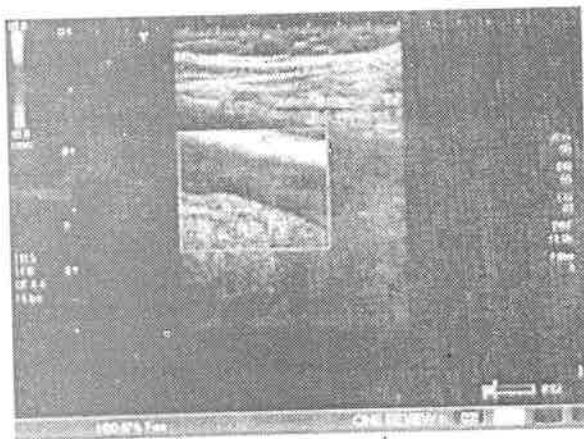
Doppler ultrasound showing a big thrombus throughout the length of the right femoral vein (RT-FV).
